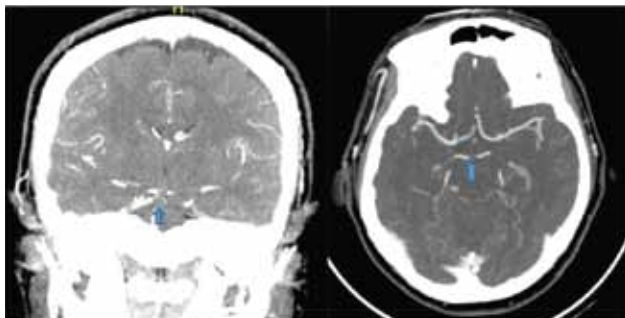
Cerebral CT angiogram, coronal and axial views, showing partial occlusion of the tip of basilar artery (shown by arrow).
